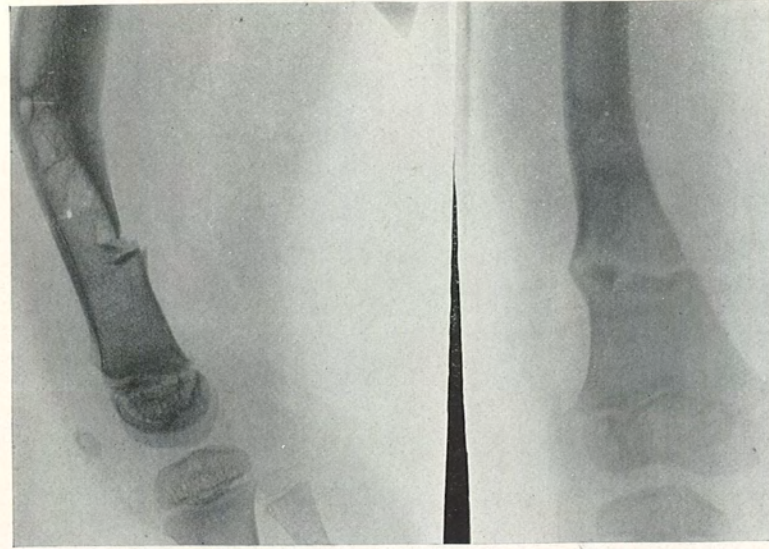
Osteomalacia. Discovered accidentally after radiograph for incomplete fracture caused by stumbling. Note compensatory hypertrophy of femur, bracket formation. Female, aged three.
